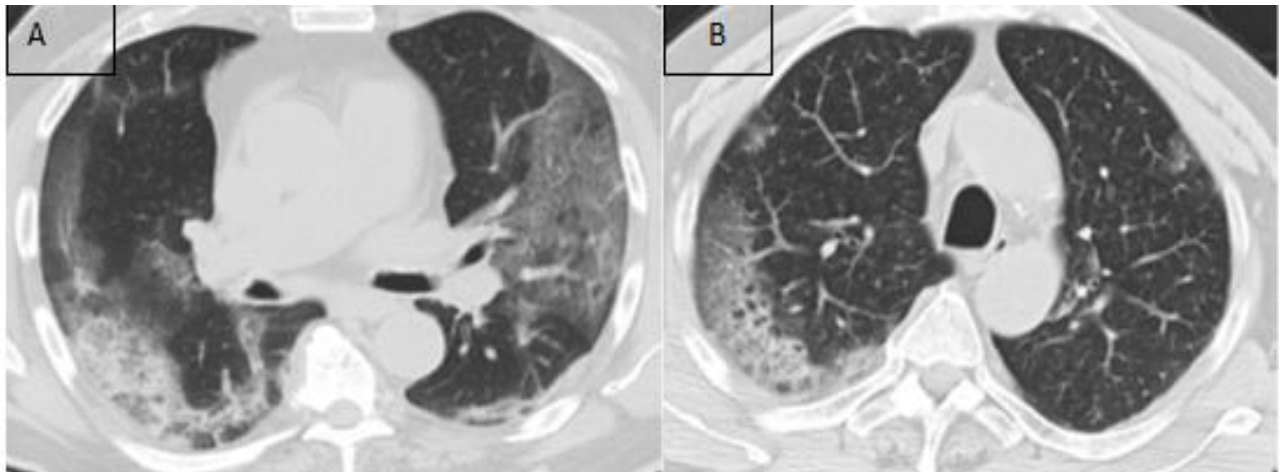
Chest CT images show consolidations (Chan et al., 2020a).
